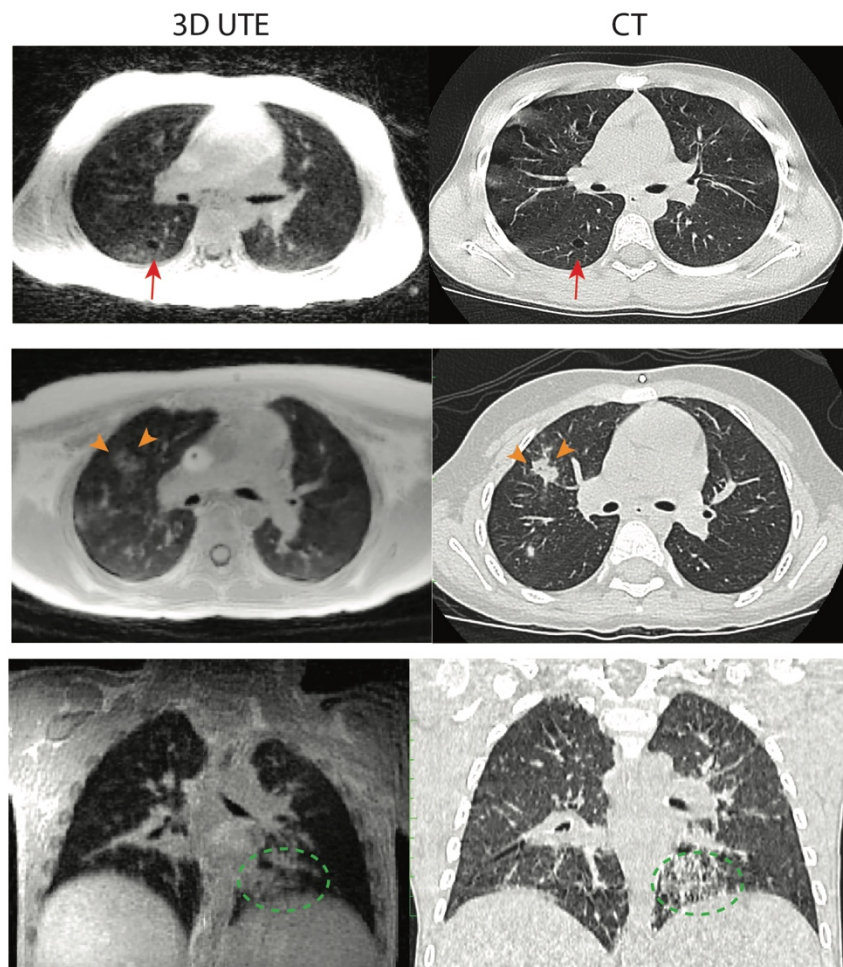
UTE and CT comparisons. UTE images of three patients with different abnormalities are compared to their CT scans. The first row images are from a 8 year-old female with Surfactant Protein C deficiency and lung disease, where small lung cyst is pointed out by red arrows. The second row shows a 5 year-old female both UTE and CT images, where a small lung nodule is surrounded by orange arrows. The third row shows scans from 4 year-old male with systemic juvenile idiopathic arthritis who has childhood interstitial lung disease, and ground-glass opacity is circled by dashed green line.
